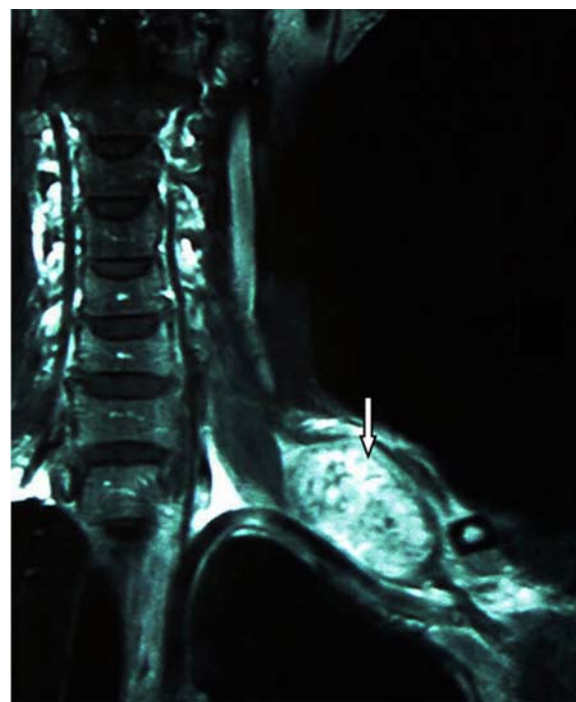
Contrast-enhanced MRI of the brachial plexus showing well-demarcated heterogeneous enhancing mass at the left brachial plexus (arrow); this is typical features of schwannoma.
